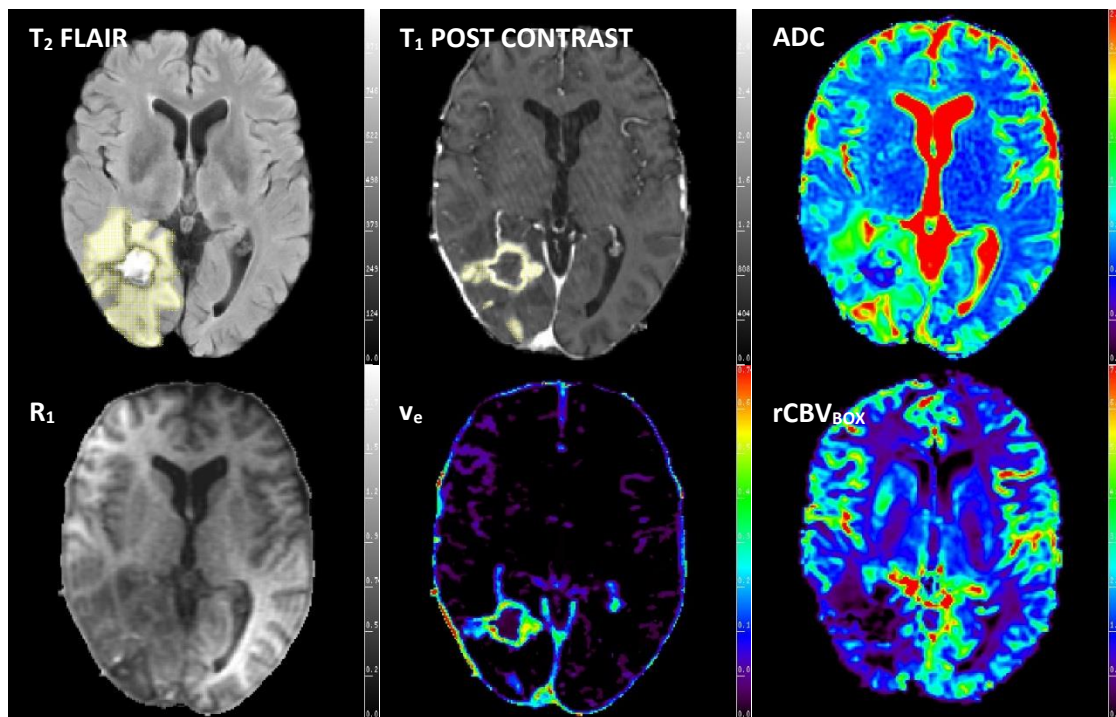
Sample postoperative, pre-chemoradiotherapy imaging at 3 weeks after surgery. FLAIR,  $T_1$  FSPGR post-contrast, ADC ( $0-2.5 \times 10^{-3} \text{mm}^2 \text{s}^{-1}$ ),  $R_1$  ( $0-2 \text{s}^{-1}$ ),  $v_e$  ( $0-0.75$ ) and  $rCBV_{\text{Box}}$  ( $0-7.5$ ) images can be seen from top left to bottom right. Part of the TUM VOI can be seen on the FLAIR imaging whilst a section of the CEL VOI can be seen on the  $T_1$  FSPGR post-contrast imaging. Note the exclusion of the post-surgical cavity from the analysis in the same manner as necrosis.
